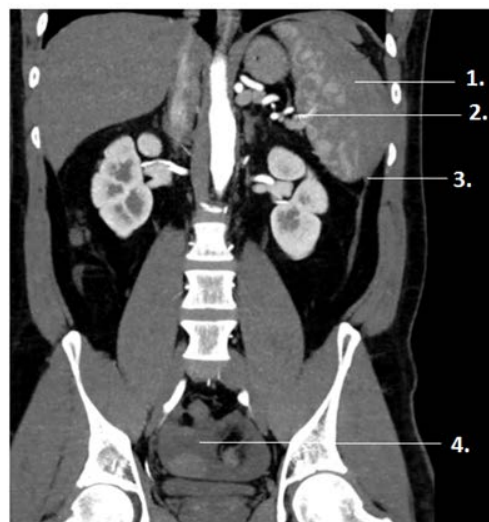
intravenous contrast enhanced CT-abdomen, coronal reconstruction, arterial phase. 1. Spleen. 2. Branch artery of the splenic artery and diffuse bleeding. 3. Perisplenic diffuse bleeding. 4. Free fluid in the lower pelvis area (excavatio rectovesicalis).
